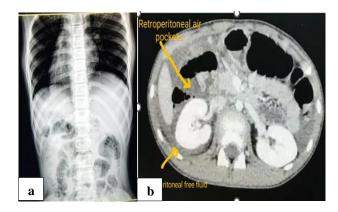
(a) Normal X-ray abdomen and (b) CT abdomen shows retroperitoneal air pockets.
